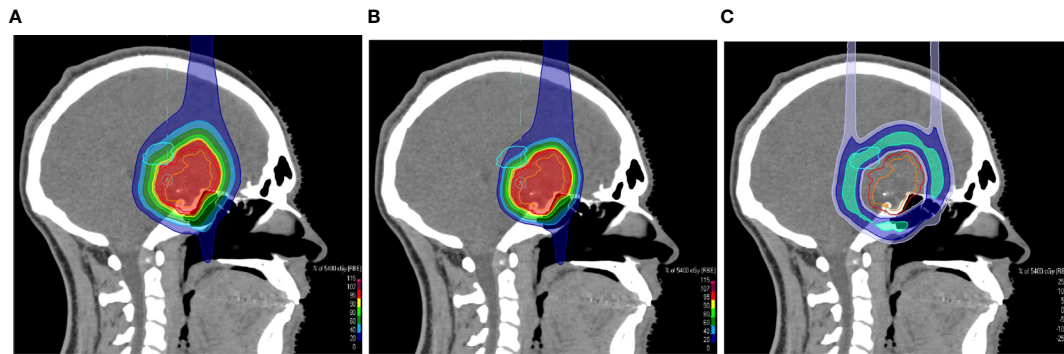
Sagittal CT slices overlaid with a colorwash representation of the dose distribution of the uncollimated plan (A) and the treatment plan with apertures (B) for the treatment of a suprasellar craniopharyngioma. The screenshots of the treatment planning in RayStation show the dose sparing of the left thalamus, which is indicated by the light blue contour. (C) shows the dose difference between the plans.
